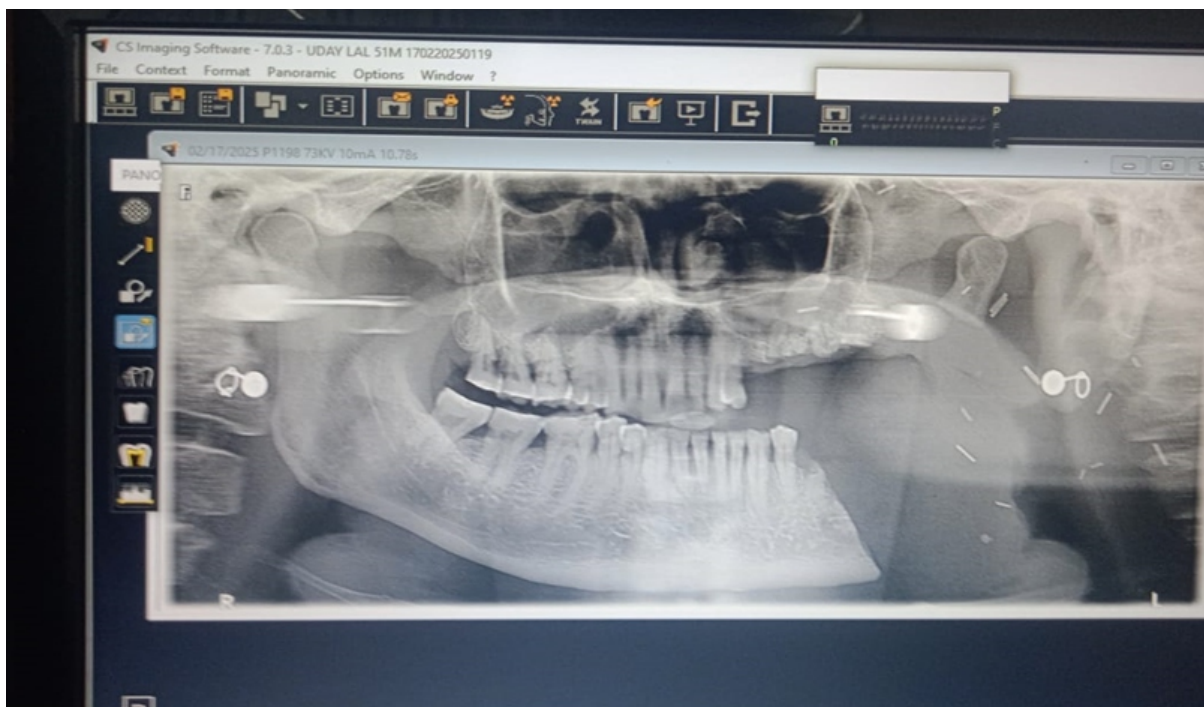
Post-op Radiograph of Hemi-mandibulectomy
